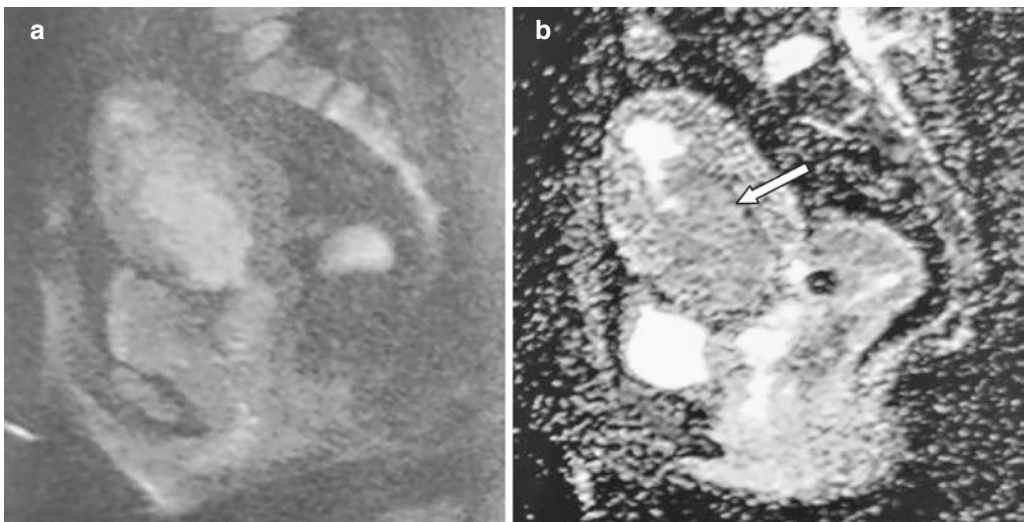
Endometrial cancer. (a, b) Diffusion weighted sagittal MRI with ADC mapping of an endometrial mass showing restricted diffusion (arrow)
